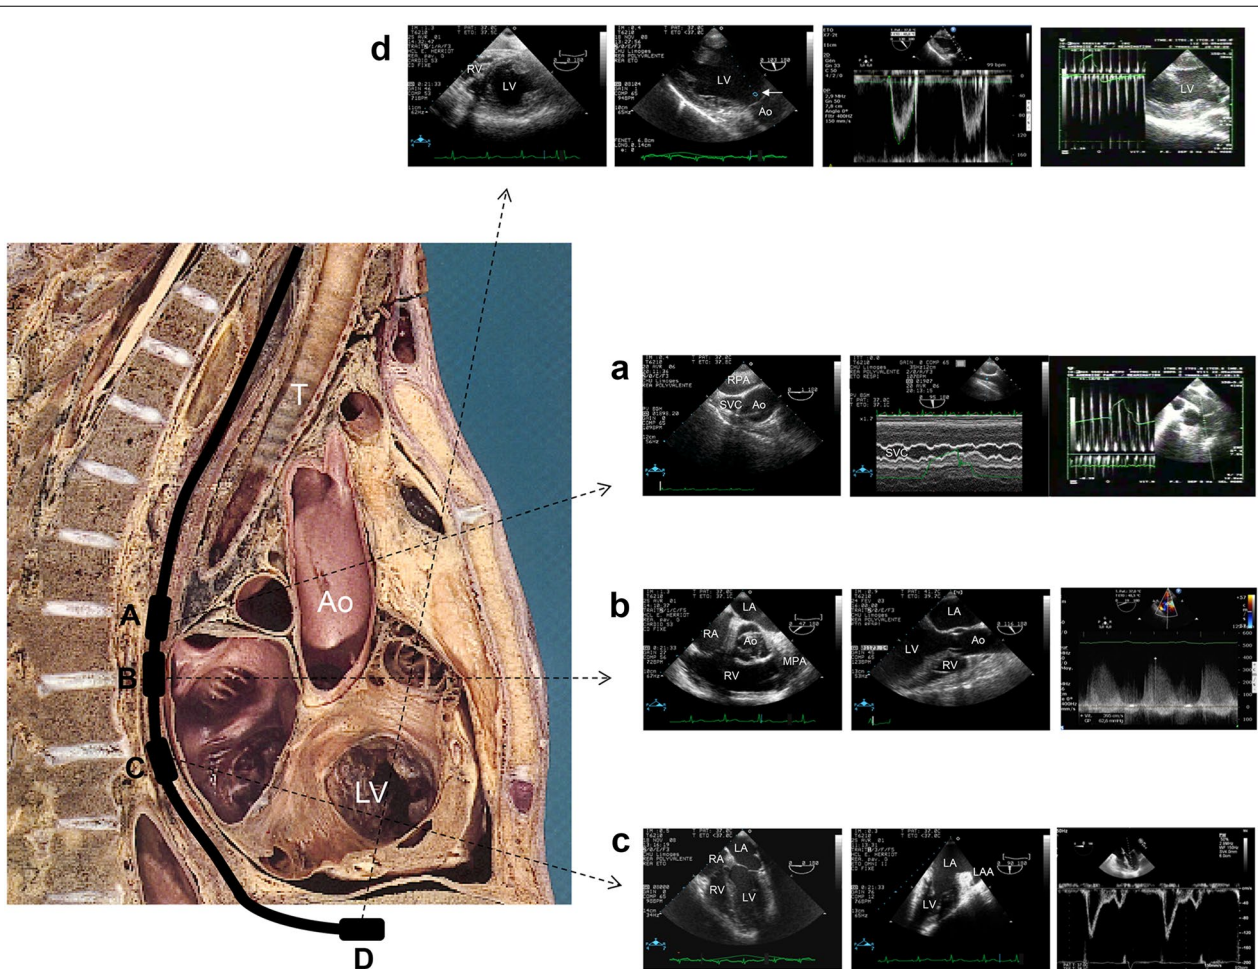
Main transesophageal echocardiographic views used to assess hemodynamics in patients with cardiopulmonary compromise. The progression of the tip of the echocardiographic probe from the upper esophagus to the stomach is depicted. *A* Upper transesophageal view of the great vessels: respiratory variations of the superior vena cava in both the short axis (*left panel*) and long axis (M-mode, *middle panel*) of the vessel and Doppler profile within the main pulmonary artery (*right panel*) can be assessed. *B* Transesophageal 40° view depicts the aortic, tricuspid, and pulmonary valves as well as right cardiac cavities (*left panel*); Transesophageal 120° view depicts the left ventricular outflow tract and both aortic and mitral valves (*middle panel*); Tricuspid regurgitation can be quantified in the 20–60° view (*right panel*). *C* Transesophageal four-chamber view (*left panel*) and two-chamber view (*middle panel*): both right and left ventricular systolic function and size can be assessed, as well as mitral Doppler profile (*right panel*). *D* Transgastric views: the short axis view of the heart allows assessing left ventricular systolic function and interventricular septal motion (*left panel*); Transgastric long axis 110–120° view allows one to measure Doppler velocities in the left ventricular outflow tract (*middle left panel, arrow*), which time velocity integral reflects stroke volume (*middle right panel*), and to assess respiratory variations of maximal Doppler velocity as an index of fluid responsiveness (*right panel*). Ao aorta, LA left atrium, LAA left atrial appendage, LV left ventricle, RA right atrium, RPA right pulmonary artery, RV right ventricle, SVC superior vena cava, T trachea Anatomical picture adapted from Atlas Anatomique Sandoz
